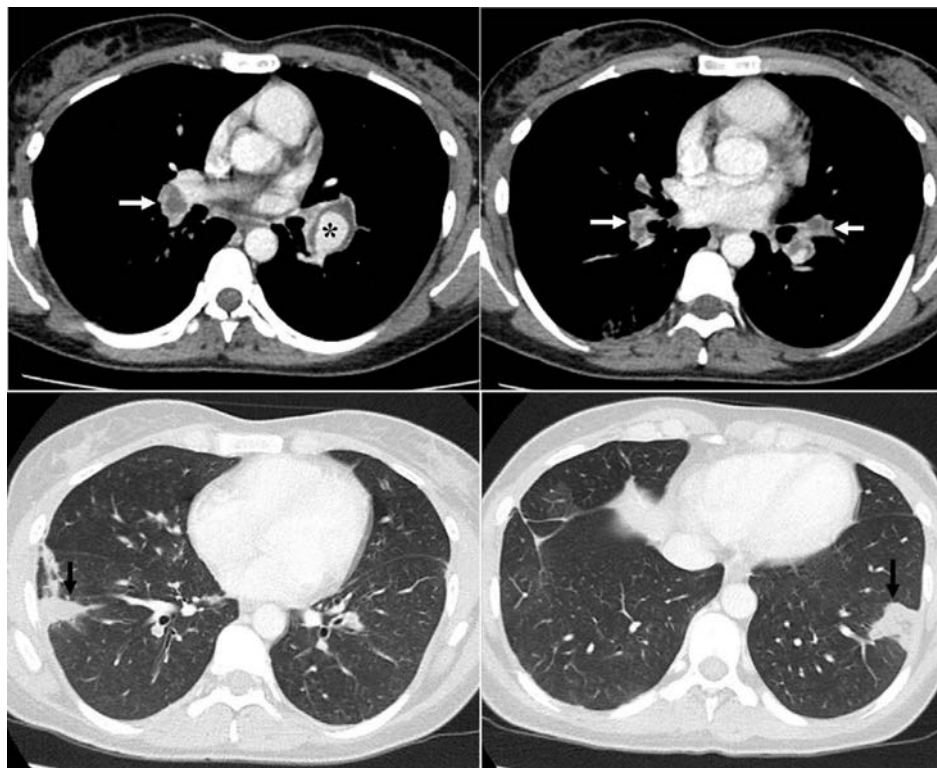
Contrast-enhanced transverse CT images. Left pulmonary artery aneurysm (*) is seen as a fusiform dilation in the left hilus, bilateral pulmonary arterial thrombosis (white arrows) is seen as vascular filling defects and pulmonary infarcts are seen as peripheral wedge-shaped opacities in both lower lobes of the lungs (black arrows).
